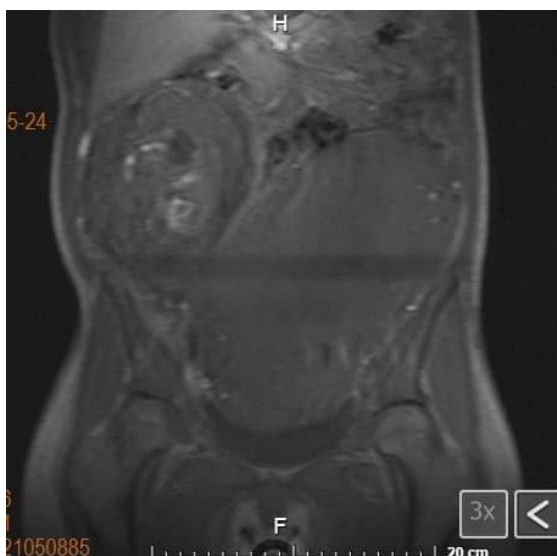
FIGURES, TABLES, AND ADDITIONAL FILES:Figure 1: Abdominal-Pelvic MRI, T1 sequence. Pregnancy findings.
